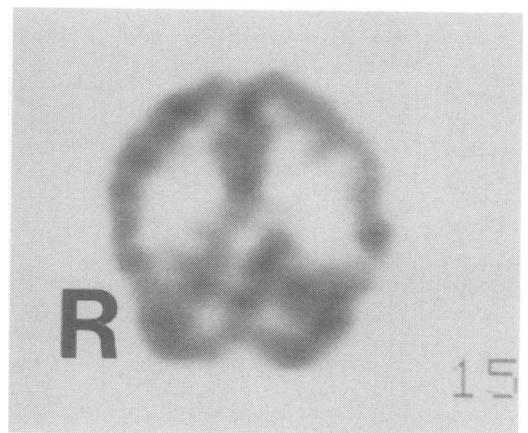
Coronal SPECT images showing hypoperfusion of the left temporal and parietal lobes.
